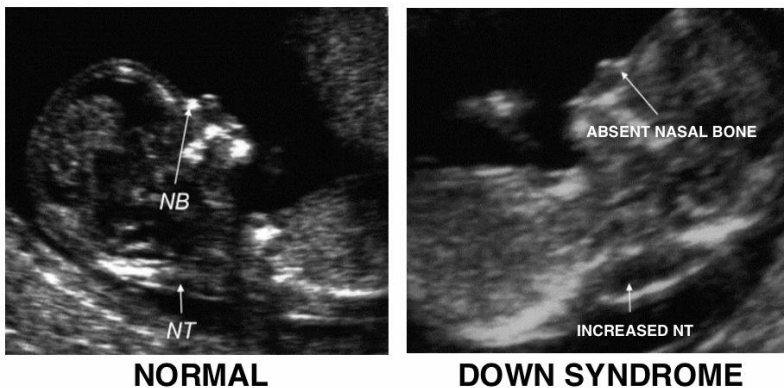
First trimester, ultrasound
